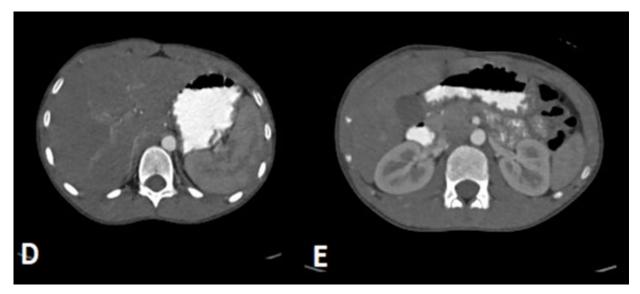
Figure D &E: Axial CT of the abdomen shows distended stomach and proximal portion of the duodenum
